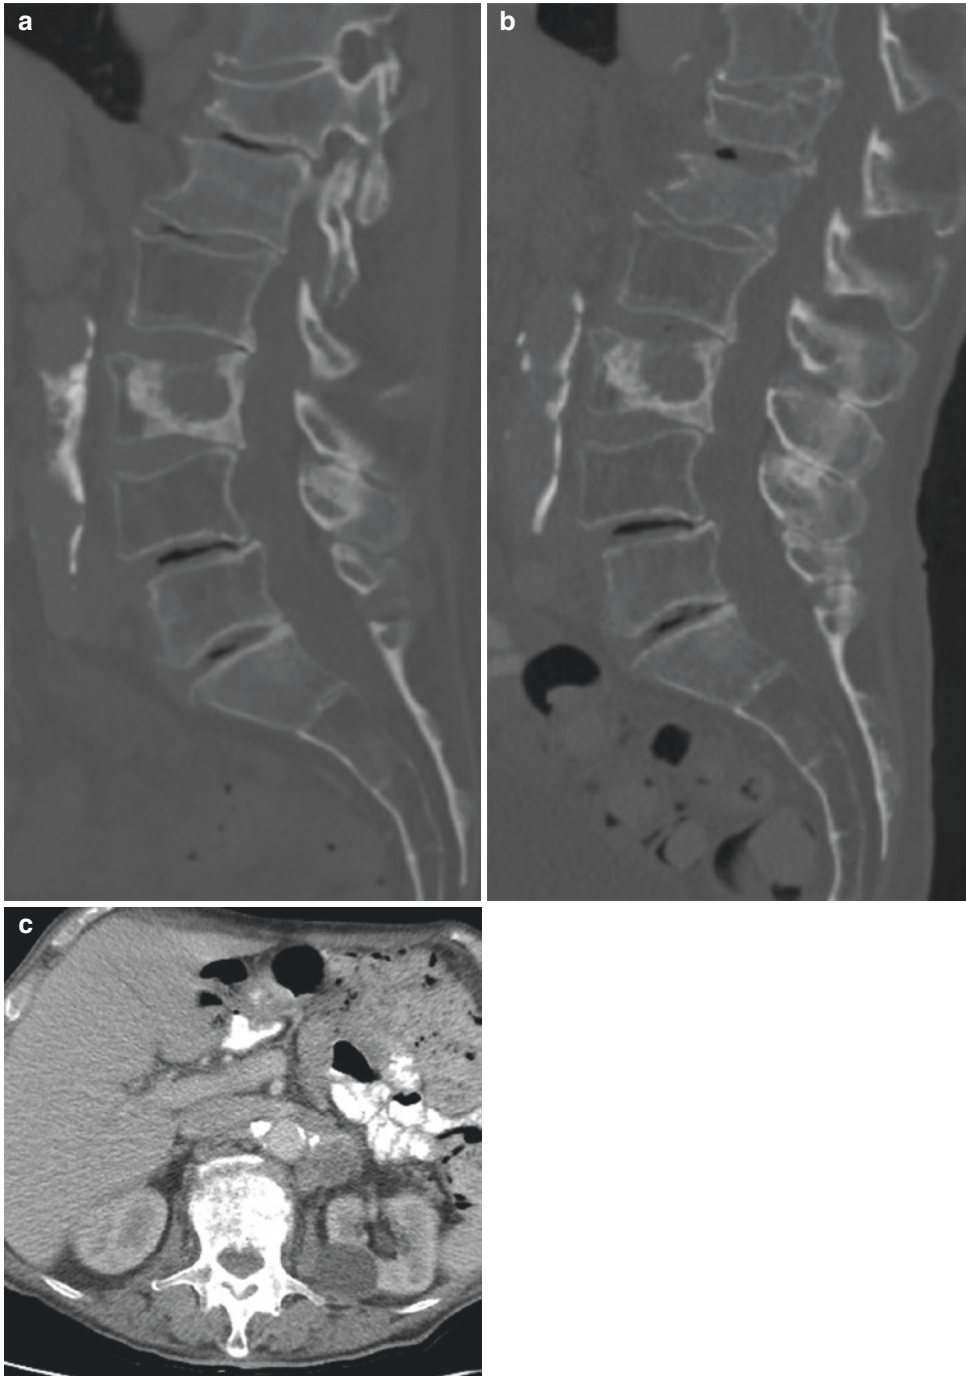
79-year-old man with metastatic, castration-resistant prostate cancer. Baseline sagittal CT (a) demonstrates a lytic metastasis with surrounding sclerosis in L3 and moderate compression deformity of T12. Follow-up sagittal CT (b) 4 months after initiating treatment with Radium-223 demonstrates no significant change in the L3
